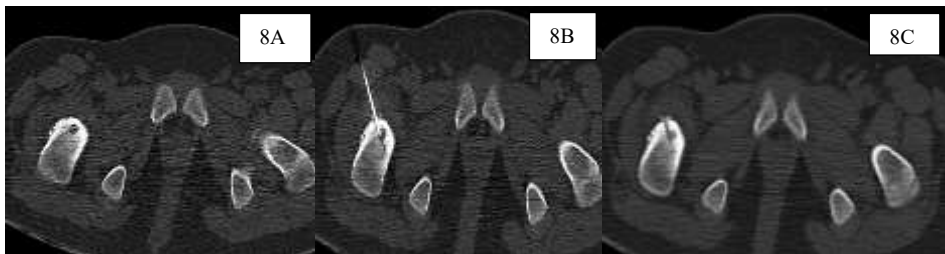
A: Axial CT scan of 10 year male demonstrating osteoid osteoma in Greater trochanter of right femur.
